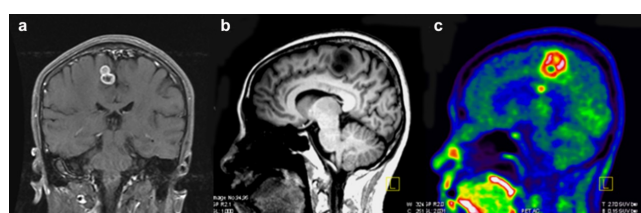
(a) Coronal CE T1WI shows the right frontal lesion has the obvious irregular rim enhancement. (b) Sagittal 3D-T1-mprage image shows the heterogenous hypointensity in the frontal lobe and the body of corpus callosum with (c) increased MET uptake (SUV_{max} up to 2.76 and 2.08, respectively).
